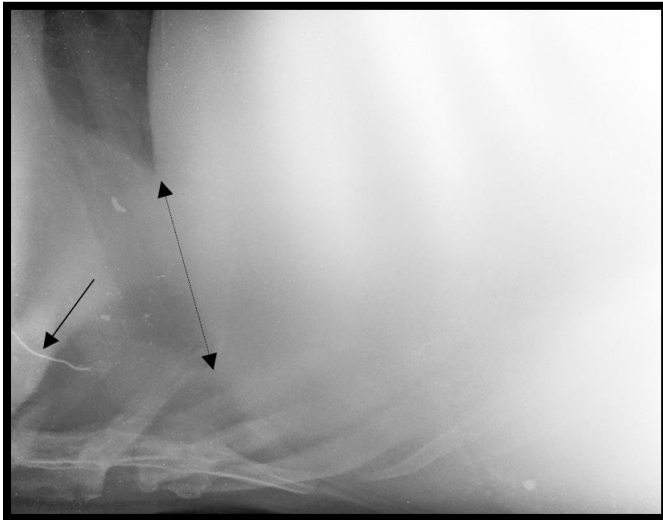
Radiograph showing DH with metallic wire in reticulum.
